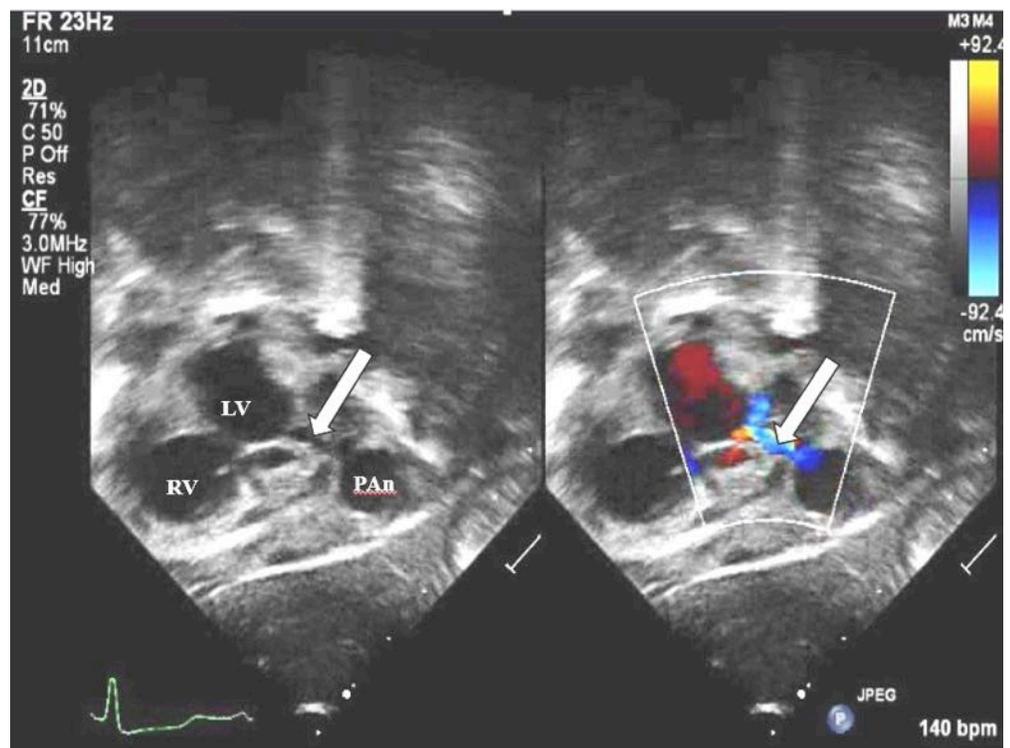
Echocardiogram; subcostal coronal views showing right ventricle (RV), and left ventricle (LV) communication with the LV pseudoaneurysm (PAn) through a fistulous connection (arrow).
